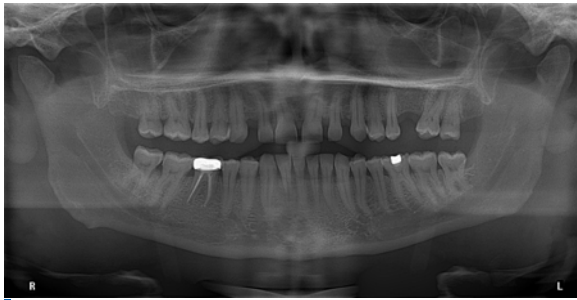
Orthopantomogram, father.
